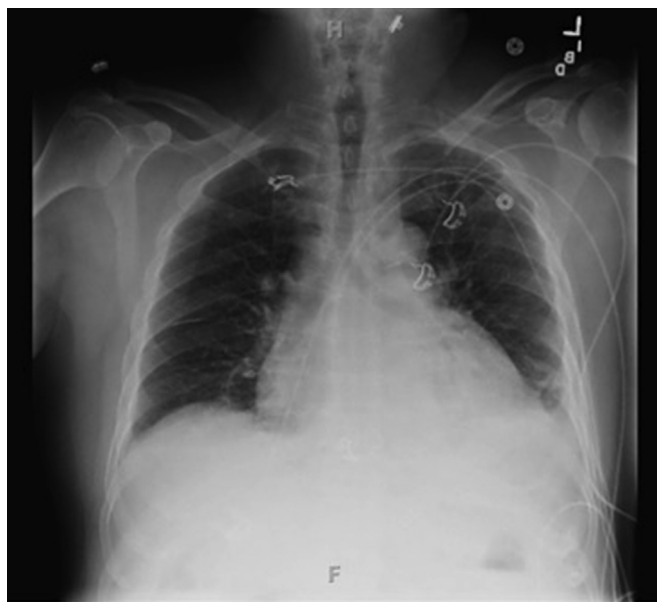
Chest Radiograph – A chest radiograph exhibiting an enlarged cardiac silhouette and blunting of the costophrenic angles bilaterally.
